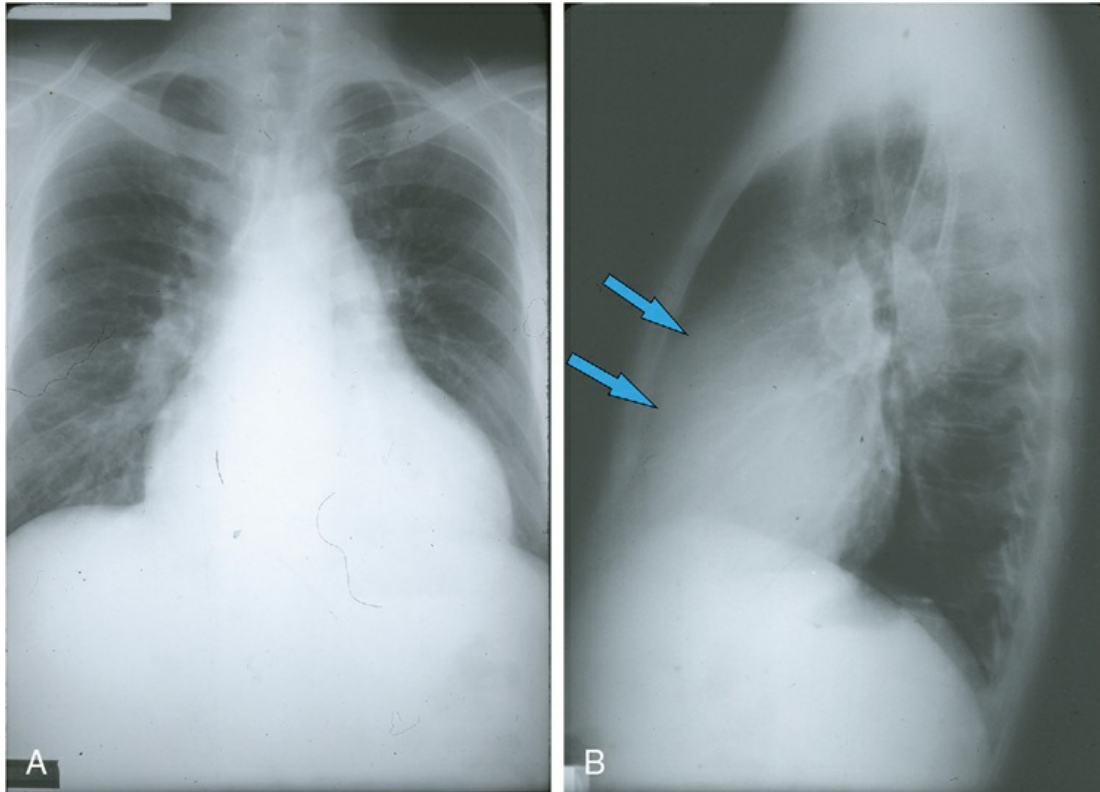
Chest radiograph of a patient with right ventricular enlargement due to pulmonary hypertension. A, Posteroanterior (PA) view showing cardiomegaly. B, Lateral view demonstrating bulging of the anterior cardiac border due to an enlarged right ventricle (arrows).
